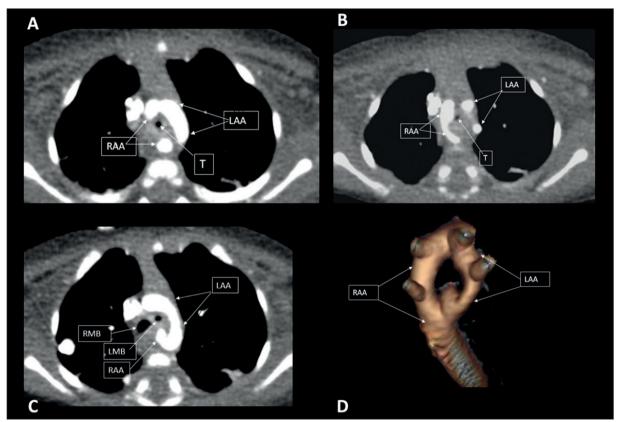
Axial CT-Angiography of the patient (A, B, C); 3-D reconstruction (D). Dominant LAA compression and narrowing of T and LMB, without fistula. RAA: right aortic arch; LAA: left aortic arch; T: Trachea; RMB: right main bronchus; LMB: left main bronchus.
